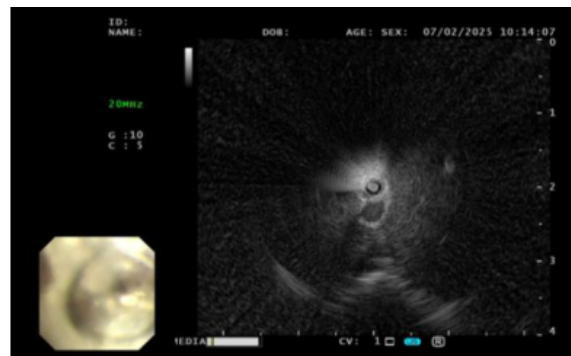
Ultrasound bronchoscopy 1 image of the left upper lobe of the patient.
